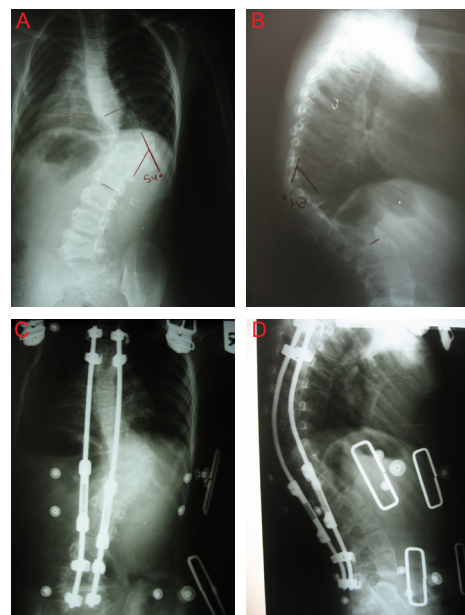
A 7-Year Old Patient With Early Onset Scoliosis Treated Using Dual Growing Rods. (A & B) Preoperative posteroanterior and lateral x-rays; (C & D) Posteroanterior and lateral x-rays taken 3 years after the first procedure with no complication.
